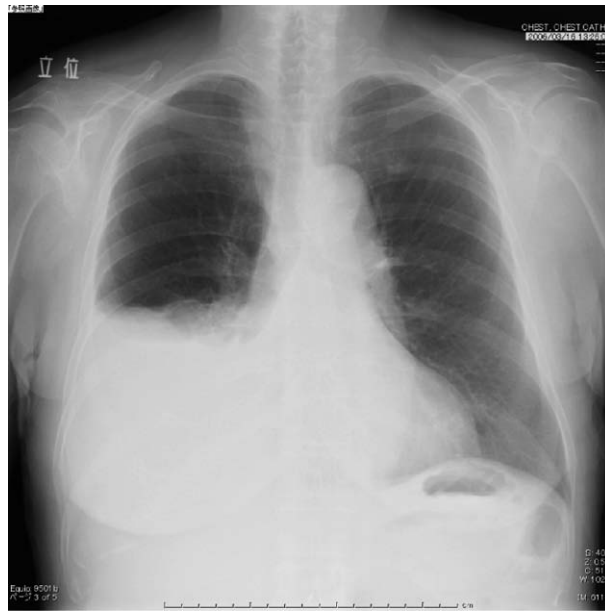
Chest roentgenogram on admission.
